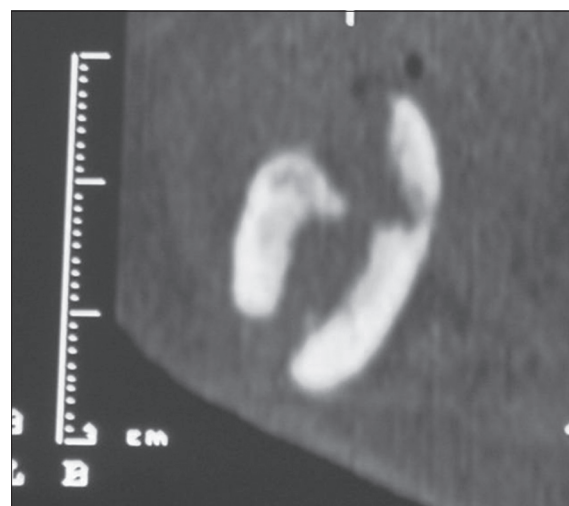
Bucco-lingual CT images further demonstrate perforation of the buccal cortical bone.
